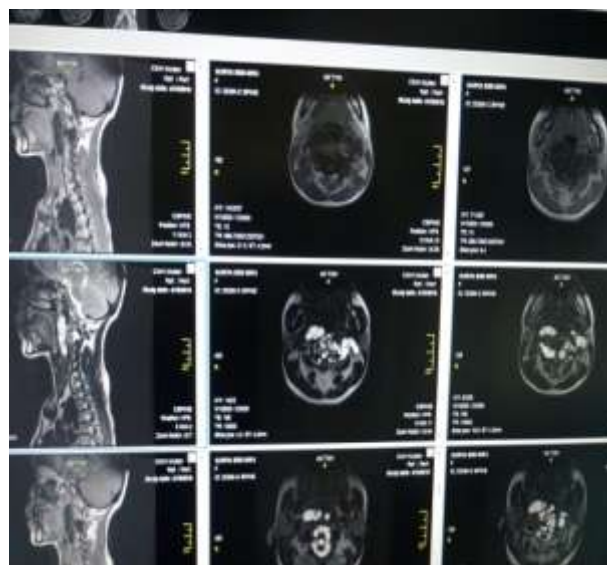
Sagittal and axial T1W and T2W MRI images showing large bunch of multiloculated cystic lesions, predominantly involving prevertebral regions with extension into bilateral neural foramina at C1 and C2 level with mild cord compression.
